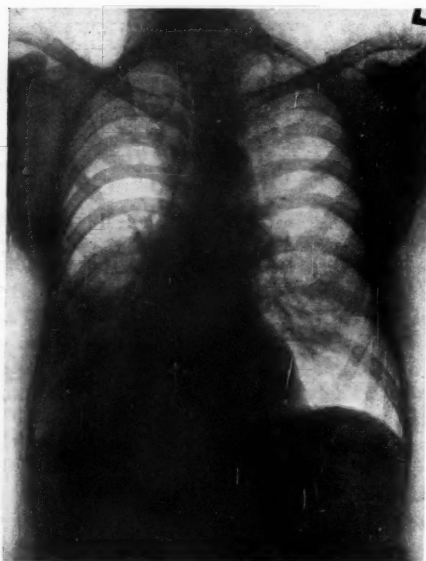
Radiograph of patient referred as "carcinoma of the right lower lobe". The radiological appearances are typical of a collapsed airless right lower lobe, and might well be due to a carcinoma obstructing the lumen of the bronchus.
